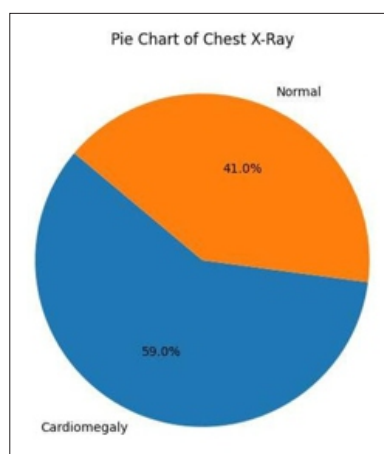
Distribution of Patients Based on Chest X-Ray Findings
